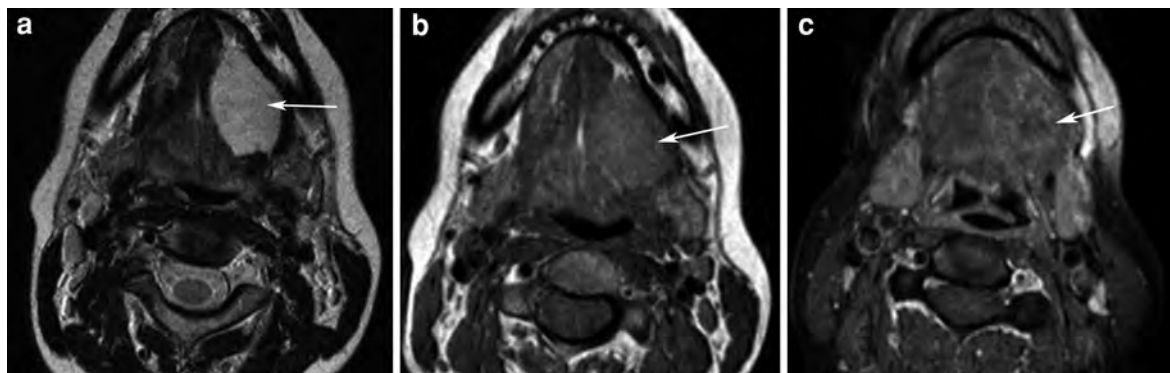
Adenoid cystic carcinoma of the left sublingual gland: huge mass appearing hyperintense on T2-weighted image (arrow, a), hypointense on T1-weighted image
